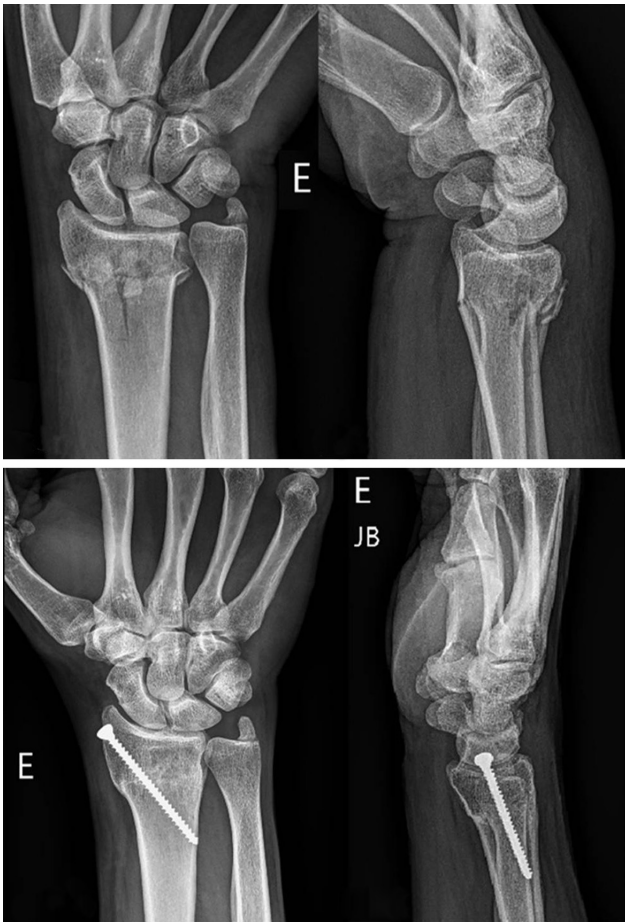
Pre- and postoperative radiographs of fractures treated according to the presented technique.
